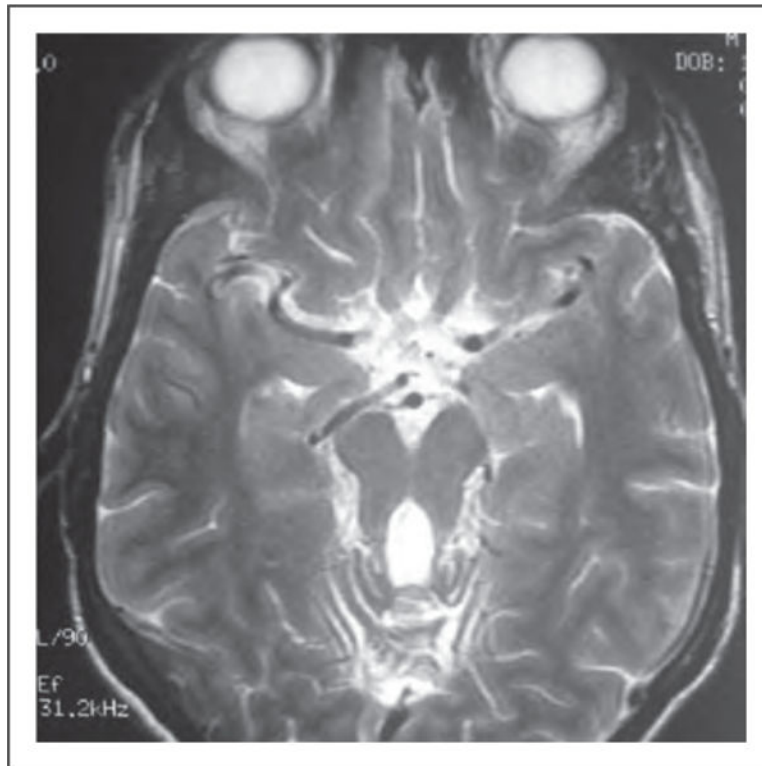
Brain MRI, T2-weighted, axial view. Molar tooth sign, Joubert's syndrome. Adapted with permission.
